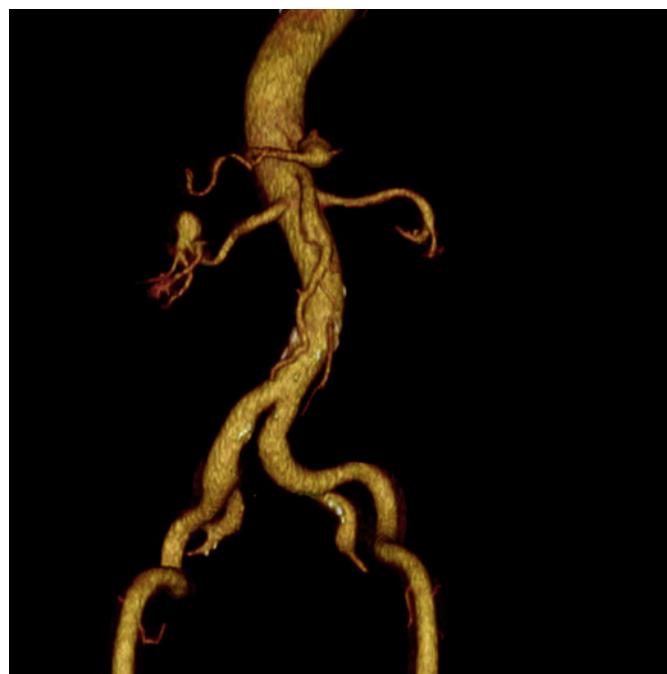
CT scan showing bilateral renal masses and right RAA. RAA, renal artery aneurysm.
